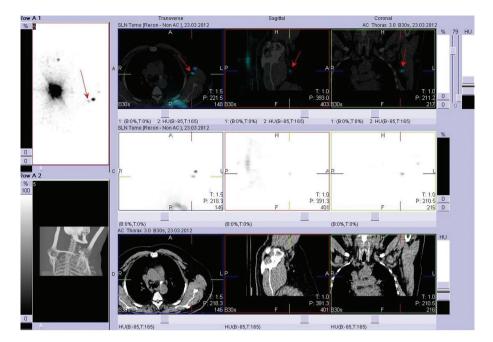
The same patient as in the figure 1 and 2. Fusion of SPECT and CT. Exact localization of the second SLN in the left axilla
